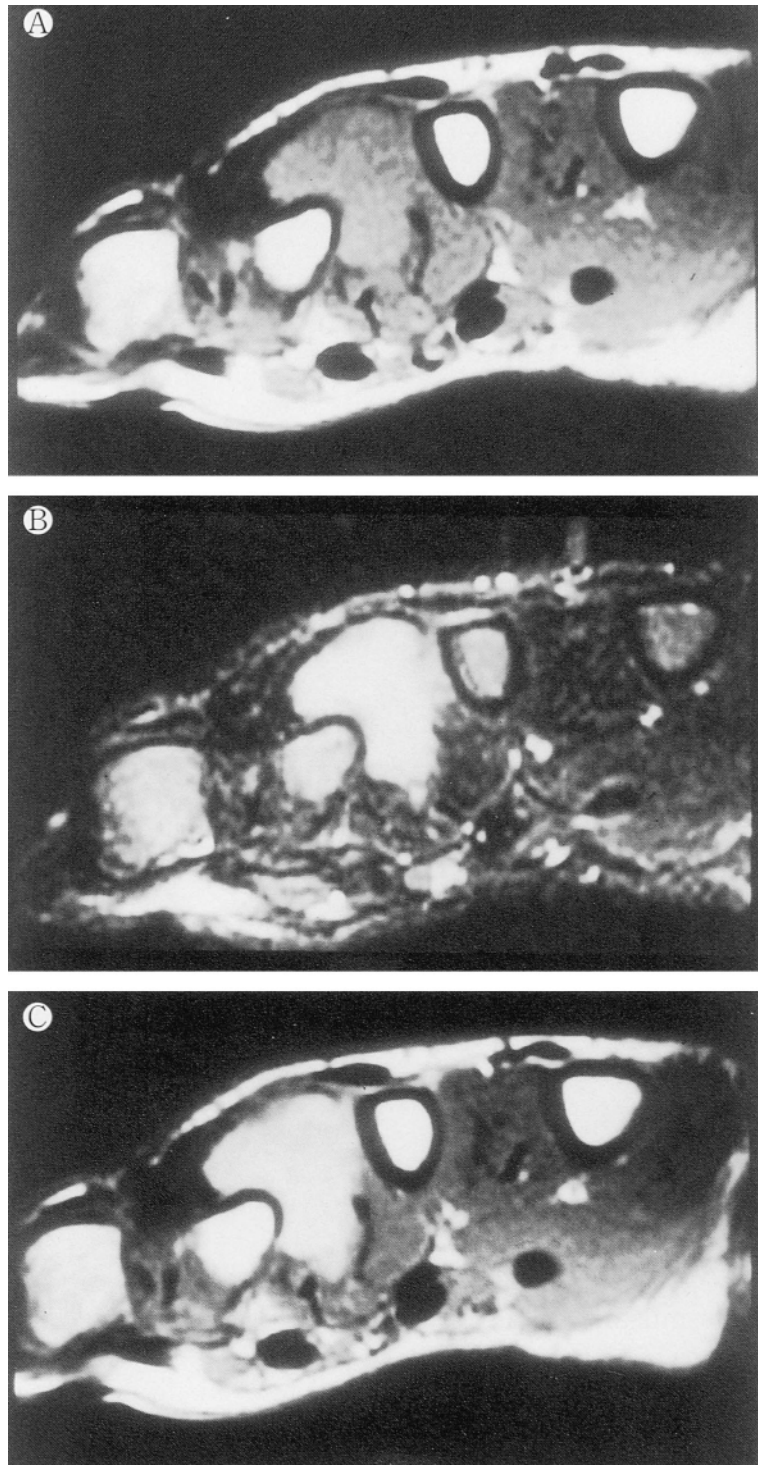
A: T1-weighted image. B: T2-weighted image. C: post gadolinium MR Images. The lesion revealed a low signal intensity on T1-weighted image and a high intensity on T2, and marked and homogeneous enhancement by gadolinium.
